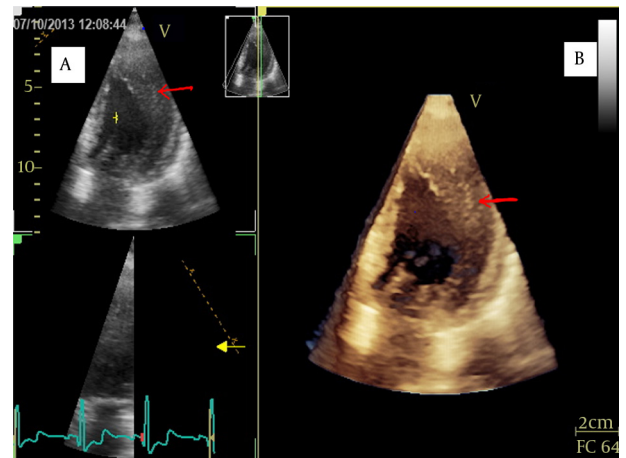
Three-Dimensional Echocardiography Clearly Distinguishes the Border Between the Left Ventricular Free Wall and the Base of the Anterolateral Papillary Muscles (Arrow)
